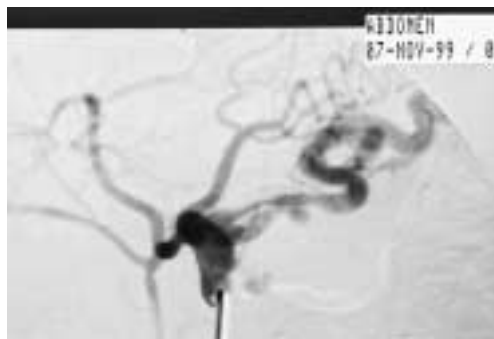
Celiac angiogram revealed extraluminal contrast deposit, 2 cm in diameter, left to markedly dilated celiac trunk; the splenic artery was tortuous and dilated with extrinsic compression of proximal part from below; the diagnosis of partially thrombosed CTA was presumed.
